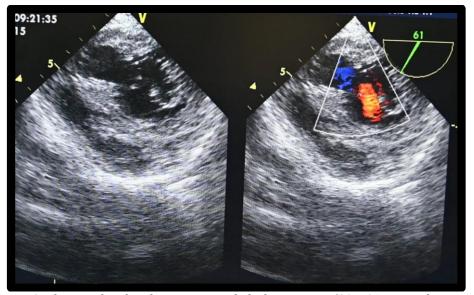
The apical 4-chamber view revealed a large cavity (30 × 21 mm in diameter).
